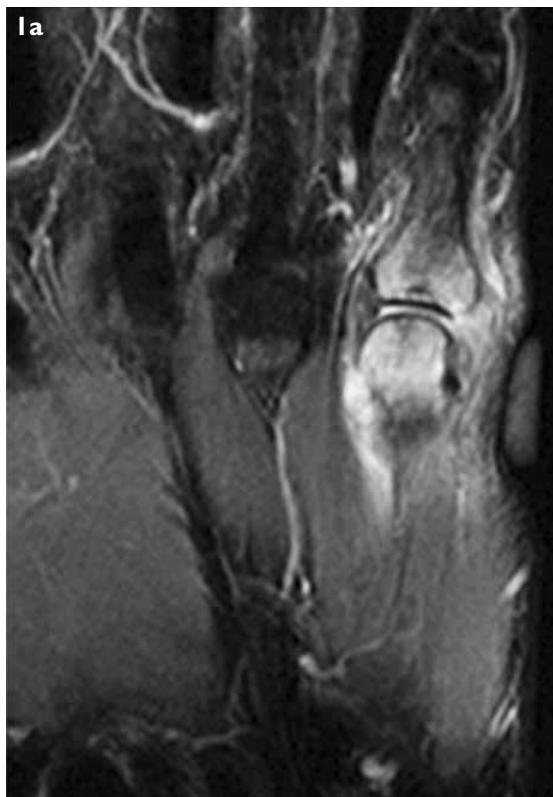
(a) Coronal TIRM image of the left hand shows marrow and periarticular oedema of the fifth metacarpophalangeal joint, with associated synovitis. (b) Post-contrast fat-saturated axial TI-WI MR image of the left hand shows thickened and enhancing synovium (white arrow), with low signal intensity tophi (arrowhead) interspersed between.
